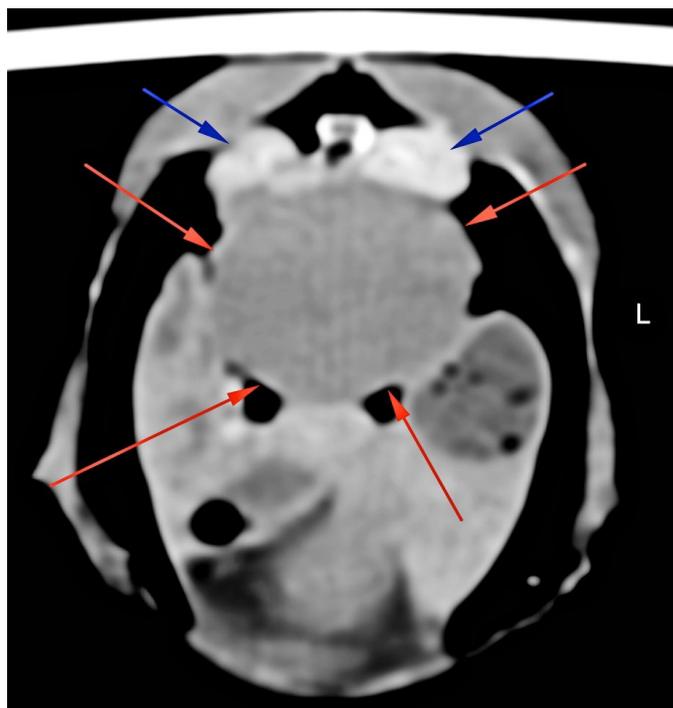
CT Transverse plane through the tumour, Case 1. Red arrows - encapsulated tumour. Blue arrows - left and right kidneys. A normal right testicle can be seen between the kidney and tumour on the right side. Compare to Figure 4.
